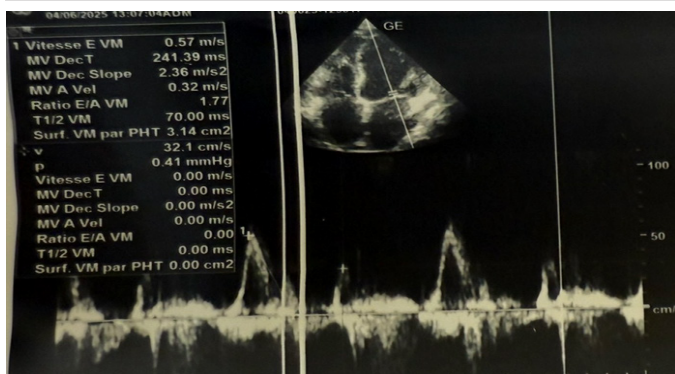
Normal Cardiac Doppler Ultrasound.
